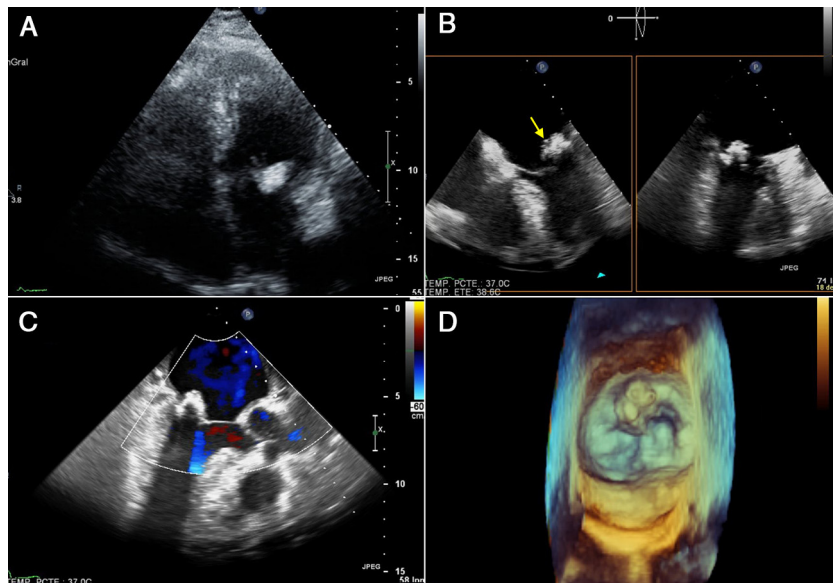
(A) Transthoracic echocardiogram showing a 2.5 cm × 1.5 cm echolucent, crescent-shaped, semilunar mass in the posterior mitral annulus. Caseous calcification of the mitral valve was diagnosed. (B) Transesophageal echocardiogram showing mobile images attached to the mitral annulus (arrow). (C) Transesophageal echocardiogram color Doppler without mitral regurgitation. (D) 3D images showing the CC of the annulus and the vegetations. Differential diagnosis with an abscess was fundamental as treatment would have been completely different (medical treatment vs. surgery).
